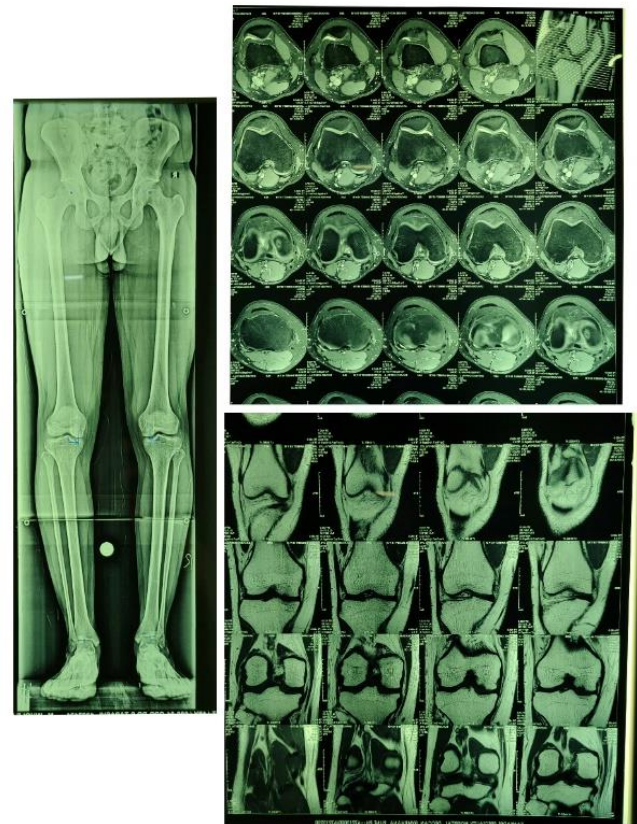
MRI Left Knee with Scanogram
